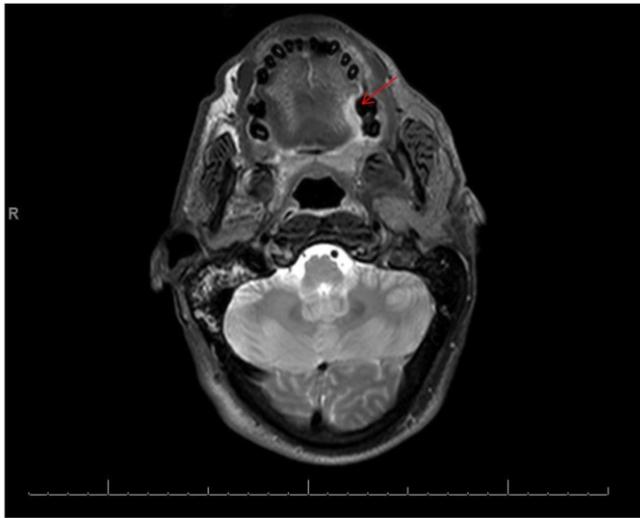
MRI of the Head and Neck area at the level of the tongue, post contrast study showing a hyperintense irregular area at the left side of the tongue 2cm in maximum diameter (T2/T1 N0).
